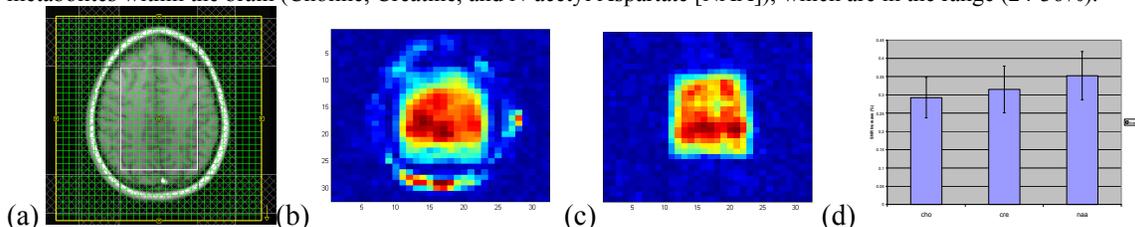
(a) is the MRI used for localization, (b) the slice based NAA spatial profile, (c) the volume localized NAA spatial profile, and (d) the SNR increase from volume to slice based EPSI.
